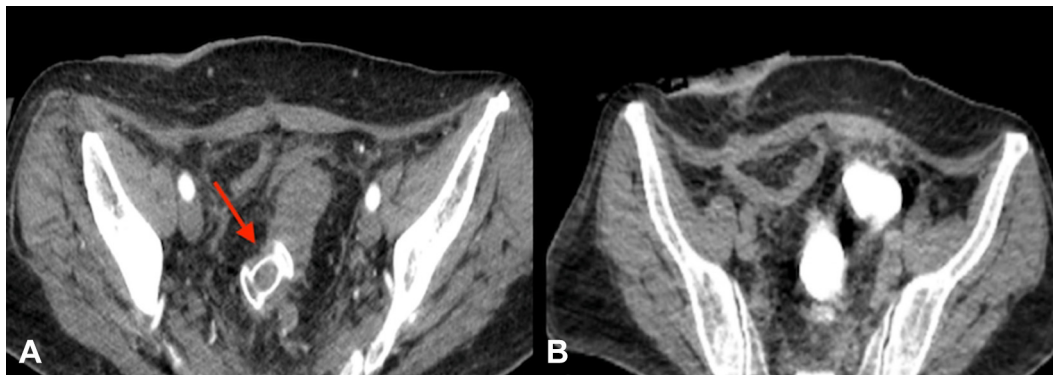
A, Contrast-enhanced CT abdomen images demonstrating patent lumen-apposing metal stent with no pelvic/paracolic collection. B, Contrast-enhanced CT abdomen images taken after administration of rectal contrast demonstrating no leak.
